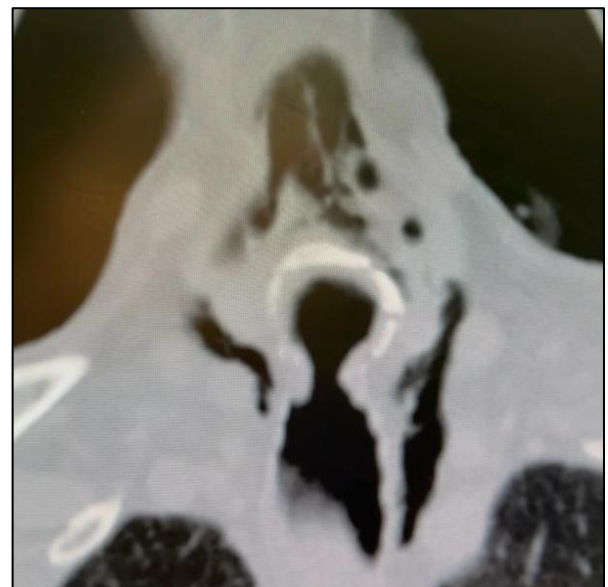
Tracheal perforation on CT cervical spine.
